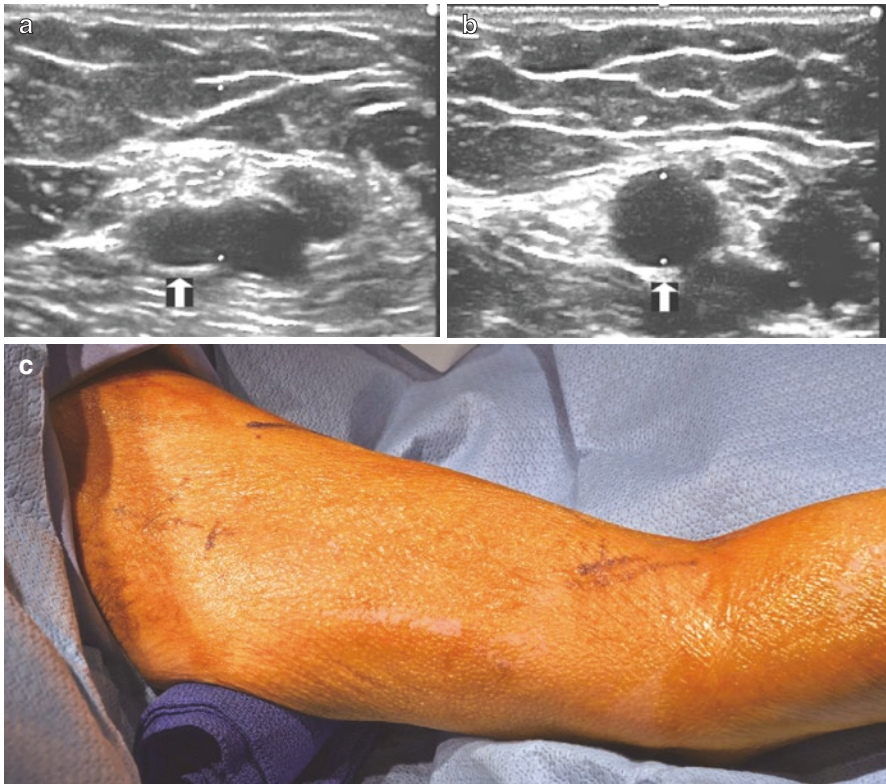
Preparation of the arm for AVG surgery. (a) Preoperative ultrasound image of the proximal basilic vein (*arrow*) adjacent to the proximal brachial artery. (b) Ultrasound image of the brachial artery (*arrow*) above the elbow crease. (c) Prepared arm ready for AVG surgery. Notice the markings on the skin planned based on preoperative ultrasound evaluation
